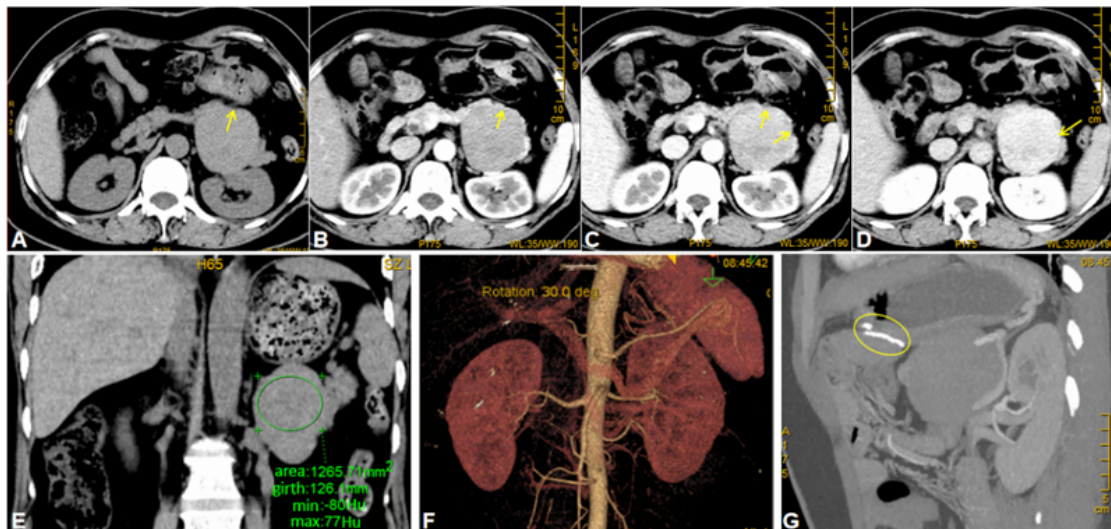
An abdominal CT showing a round soft tissue mass in the tail of pancreas. The representation of mass was relatively homogeneous in non-enhanced image (A), but becoming to in the arterial, venous and delayed periods in (B-D). A minimum CT value at -80 Hu in low-attenuation areas was detected in coronal position (E). The adjacent splenic artery and vein were displaced in the volume rendering (VR) imaging (F). The shadow of surgical clipping for radical gastrectomy was observed in multi-planar reformatting (MPR) in sagittal position (G). The yellow arrows indicate the unclear boundary of adjacent surface partly between the tumour and tail of pancreas.
